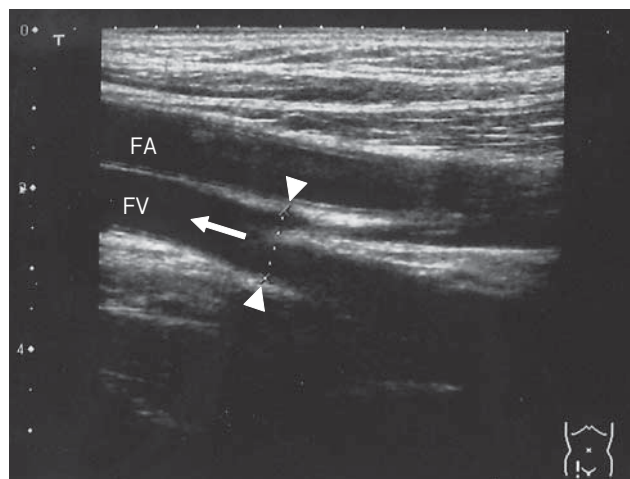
Ultrasonography of the right common femoral vein. The maximum diameter of the femoral vein (arrow head) and the velocity of the femoral vein (arrow) were detected. FA, femoral artery; FV, femoral vein.
